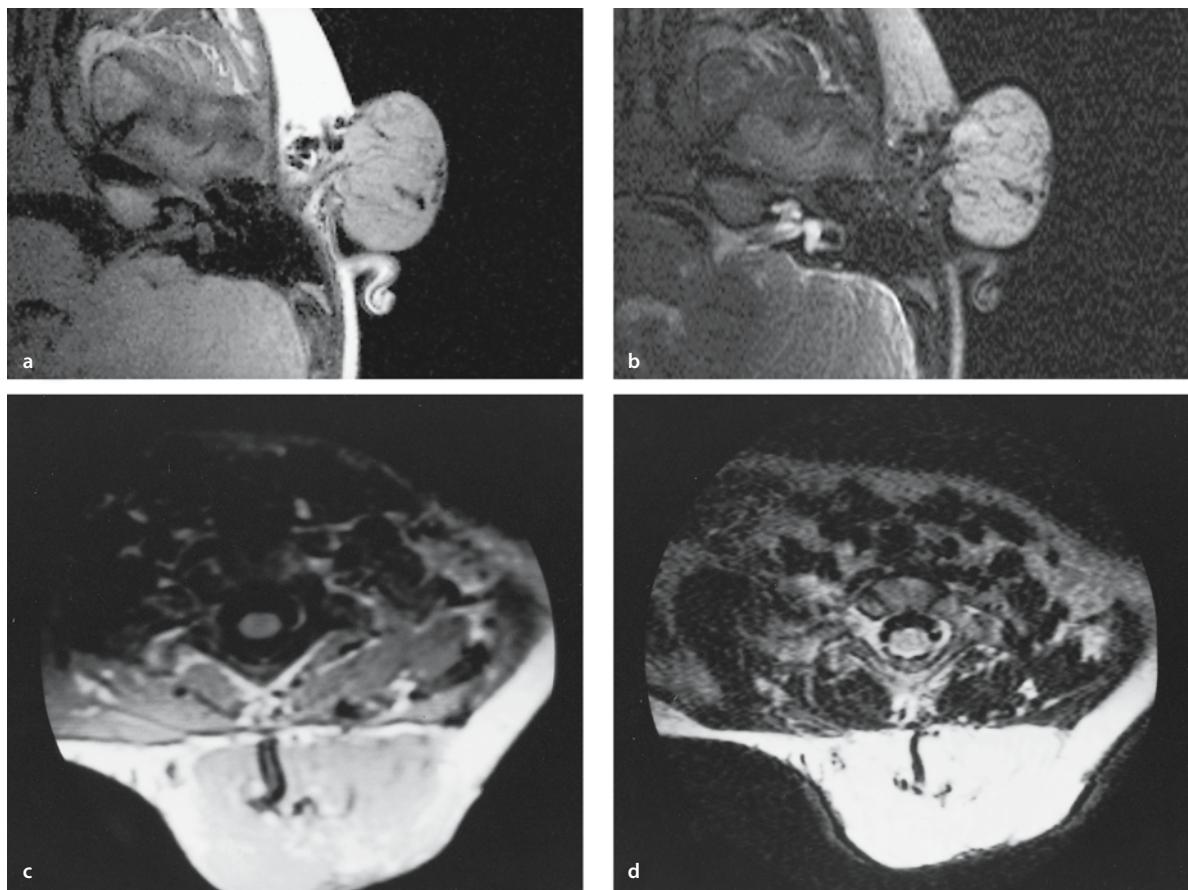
Hemangiomas of infancy. a, b Axial T1- and T2-weighted MR images in a 2-year-old girl. c, d Axial T1- and T2-weighted MR images in a 17-month-old girl. A preauricular mass that is isointense on the T1-weighted image and hyperintense on the T2-weighted image is seen (a, b). Enlarged feeding vessels are seen within the subcutis anterior to the lesion and peripherally
